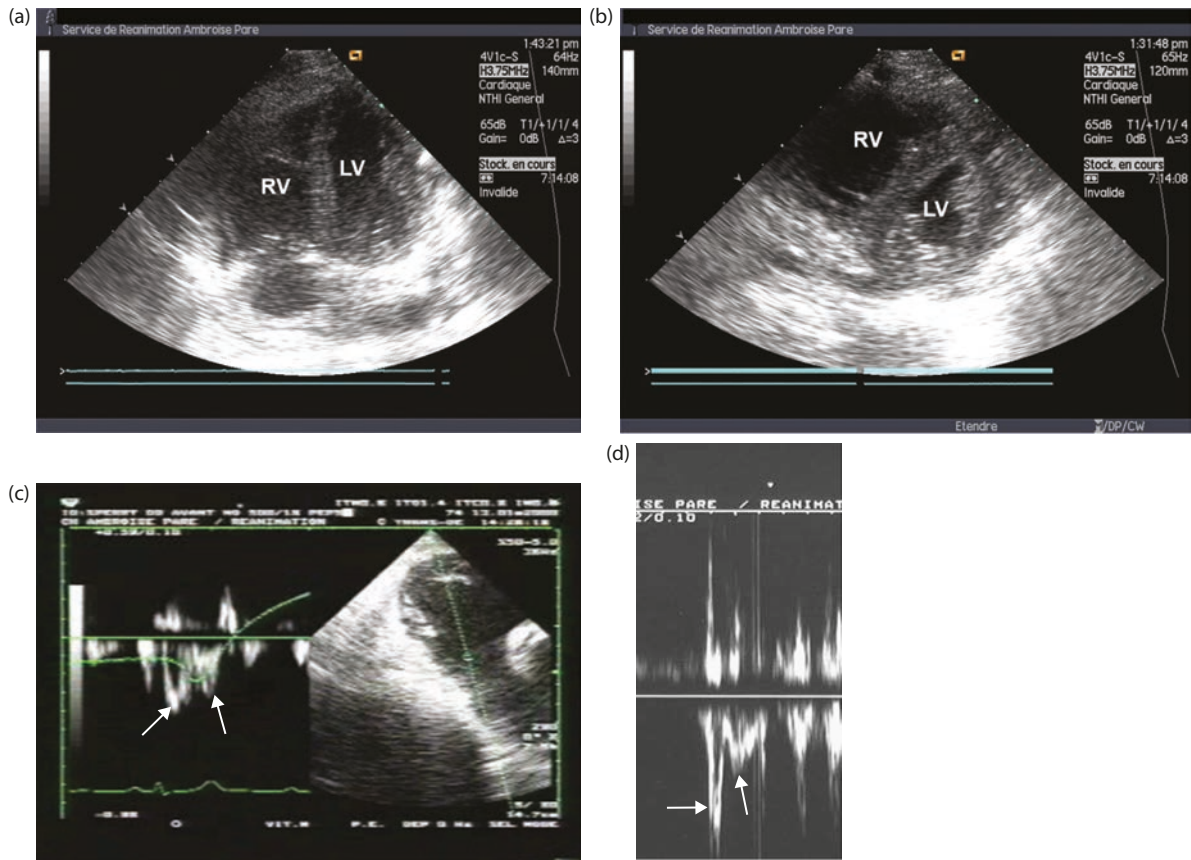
Typical pattern of acute cor pulmonale. (a) and (b) acute cor pulmonale in a patient with ARDS related to influenza. The apical four-chamber view demonstrated RV dilatation (a), whereas the parasternal short-axis view demonstrated paradoxical septal motion (b). In another patient with acute cor pulmonale related to ARDS, note the biphasic pattern of the pulmonary flow (c) (arrows). The same pattern was also seen in a patient with a massive pulmonary embolism (d). RV, right ventricle; LV, left ventricle.
